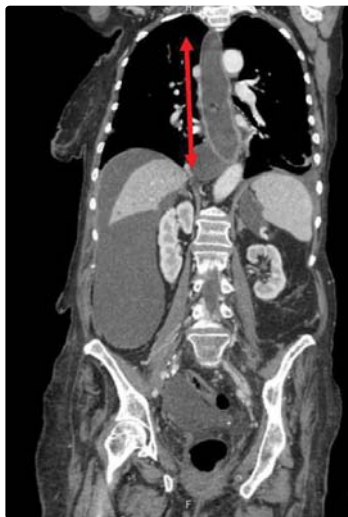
CT scan of the chest, abdomen and pelvis in coronal view. The mega-esophagus filled with debris is marked by the adjacent arrow.
